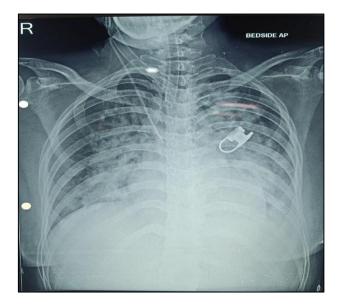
Post-operative chest X-ray suggestive of pulmonary edema.
